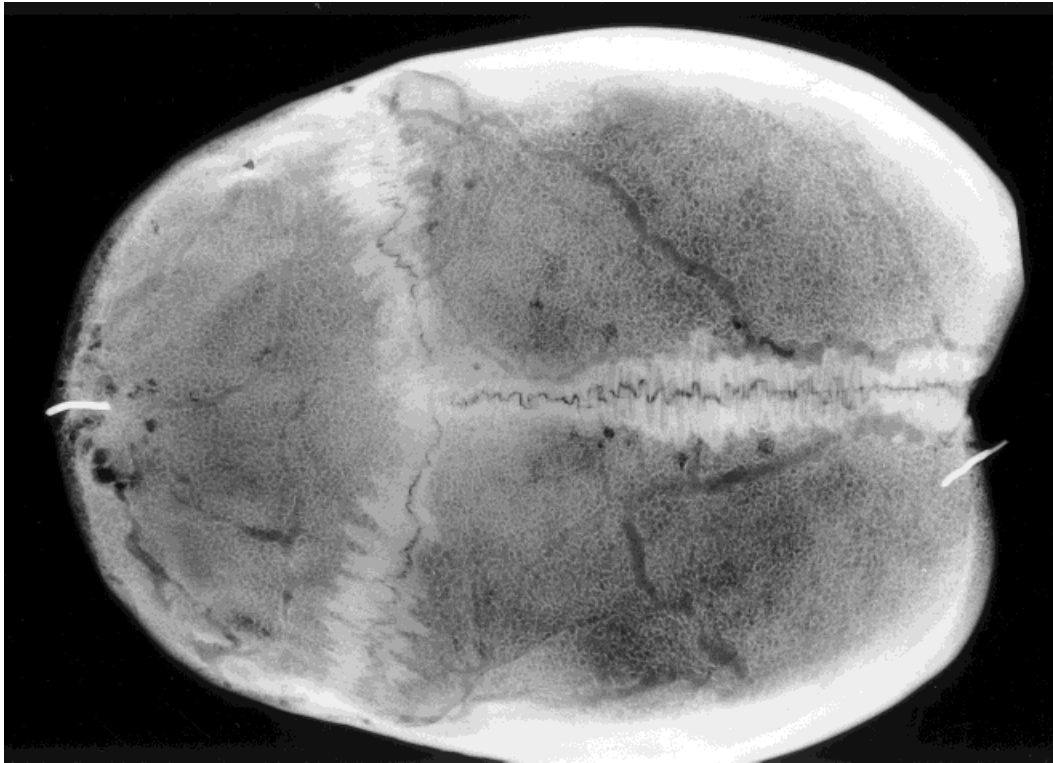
Superior-inferior x-ray view of diploic vein pattern. Two large diploic veins running parallel to sagittal sinus. Notice the lack of full symmetry between the sides.
